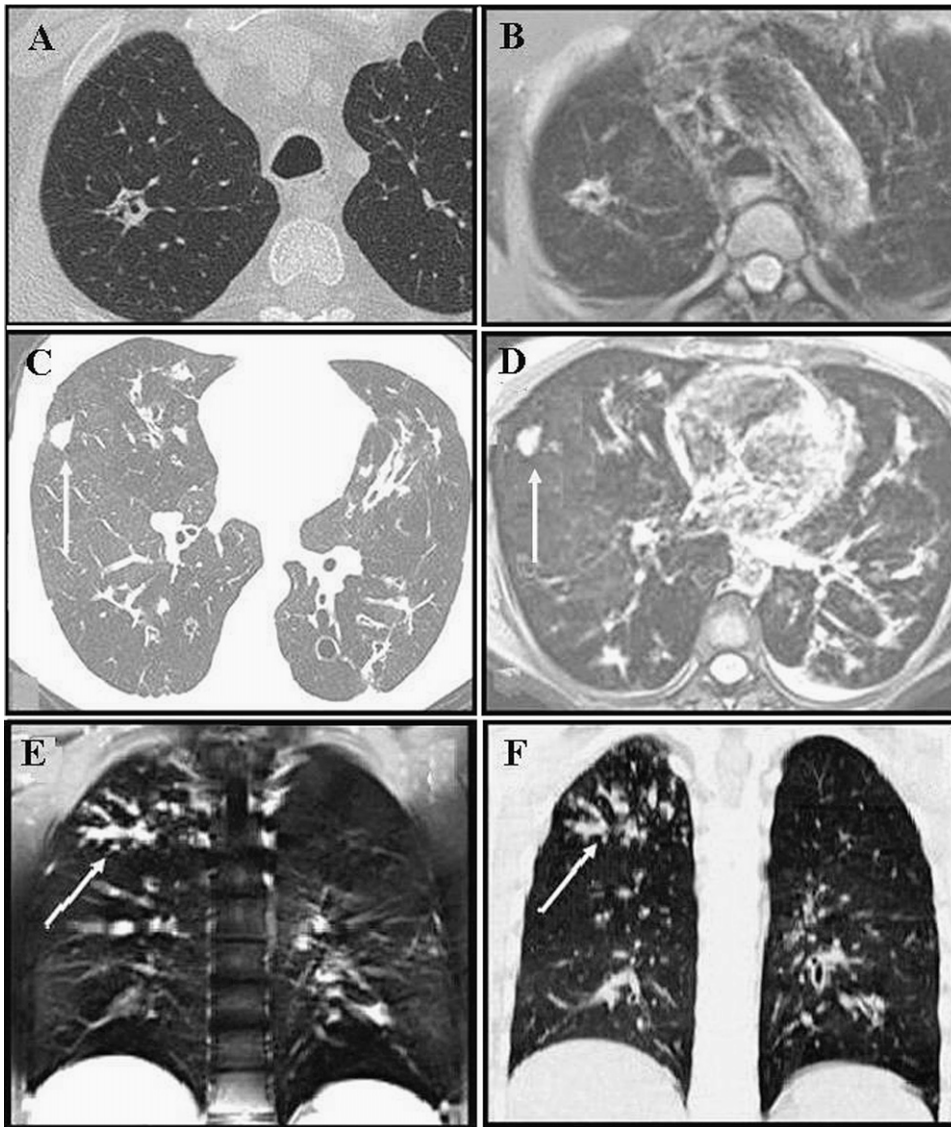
A, CT image of peripheral bronchial wall thickening in a patient with common variable immunodeficiency (CVID). B, MRI image of peripheral bronchial wall thickening in a patient with CVID. C, CT image of diffuse lung disease in a patient with bronchiectasis, bronchial wall thickening, and peripheral nodule (arrow). D, MRI image of diffuse lung disease in a patient with bronchiectasis, bronchial wall thickening, and peripheral nodule (arrow). E, MRI image from a patient with bronchiectasis and mucus plugging localized in the right upper region (arrow). F, CT image from a patient with bronchiectasis and mucus plugging localized in the right upper region (arrow).
